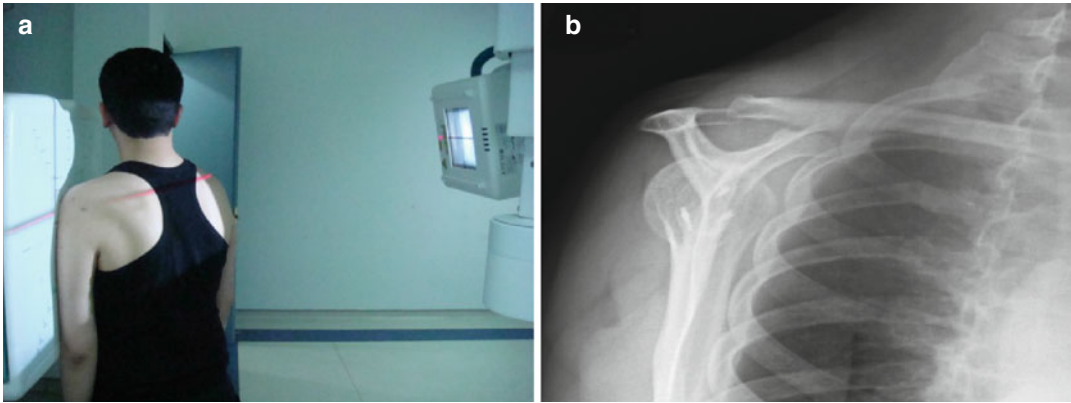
Scapular Y radiography. (a) Position of the patient and x-ray device during the scapular Y radiography. (b) Image of scapular Y radiography
